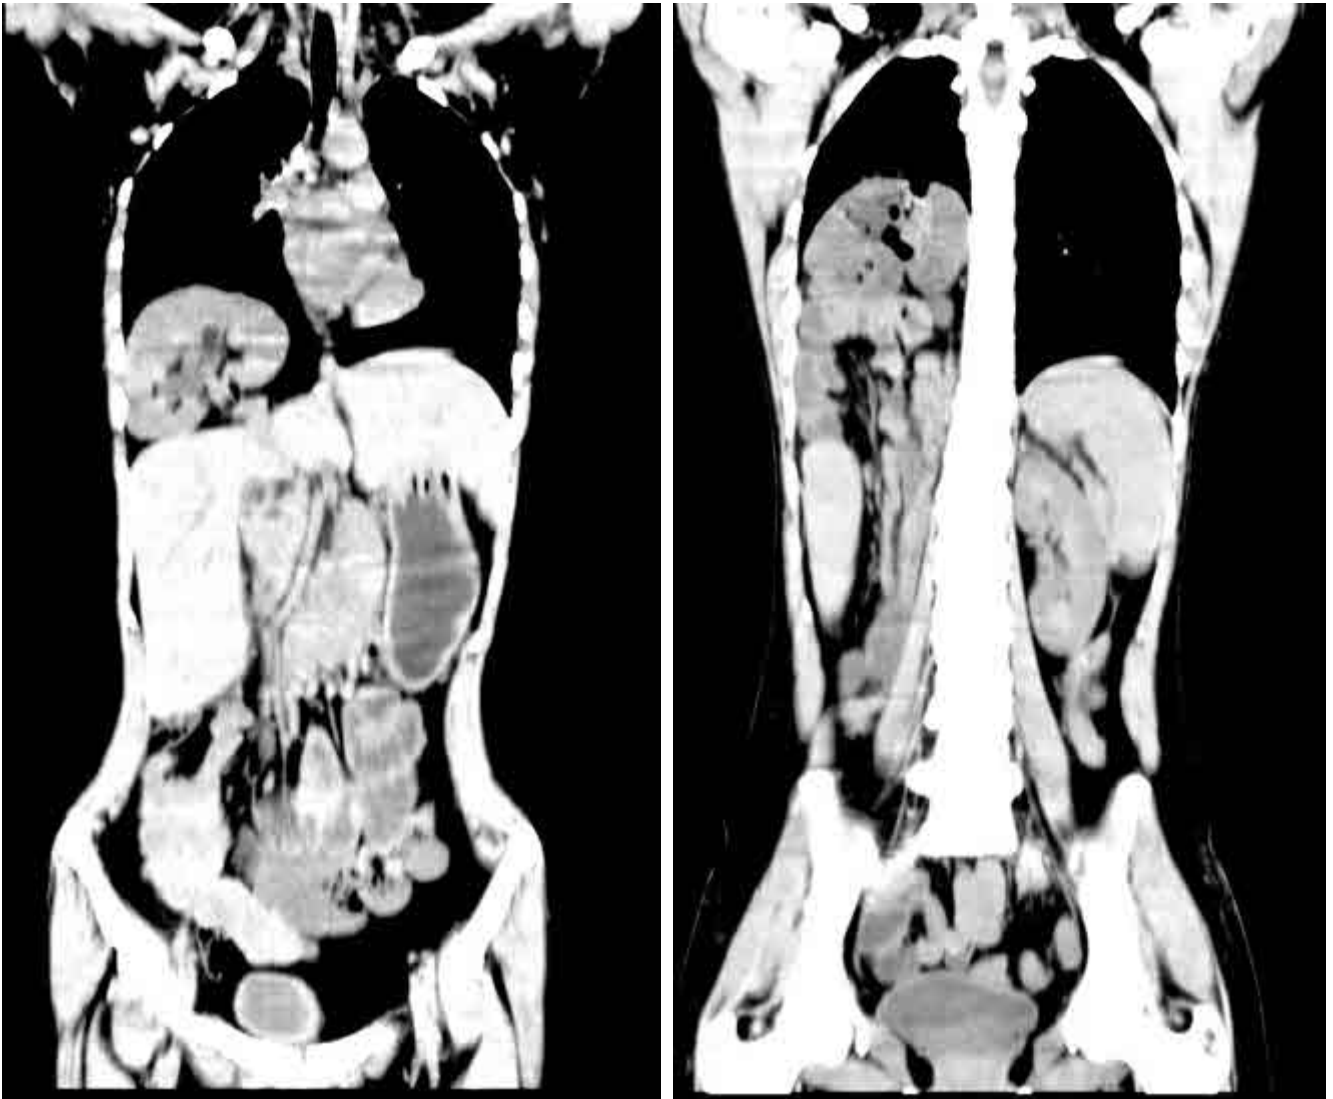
CT with oral contrast showing the ascending and most of transverse colon in the right thorax along with the right kidney
